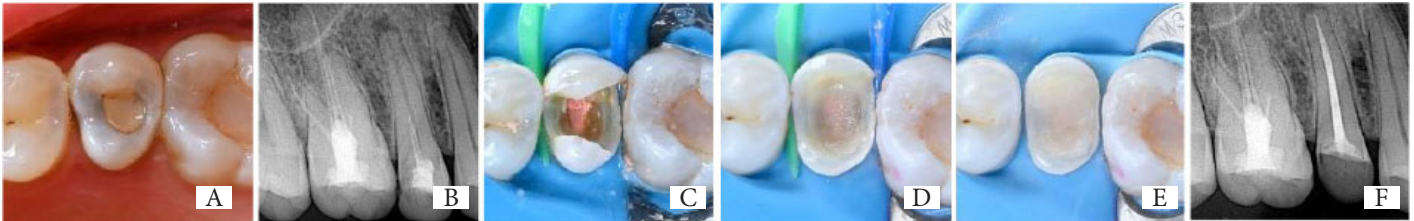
(A) Pre-operative clinical picture show old restoration leakage; (B) Radiographic showing periapical radiolucency; (C) Clinical view after obturation; (D) Application of ribbon fiber and Ever X posterior; (E) Clinical view of biobase; (F) Radiographic showing hermetic root canal filling and homogenous coronal seal biobase tooth 15.
